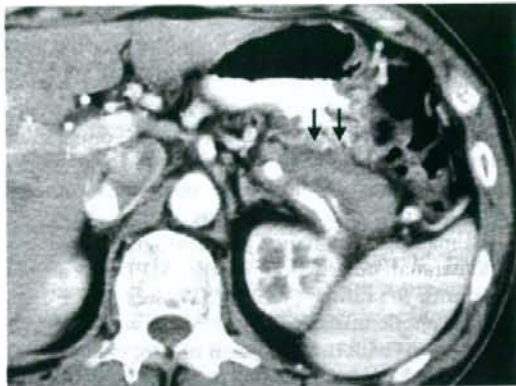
Arterial phase, contrast-enhanced computed tomography (CT) in case 4 shows a mass-like lesion in the body to tail of the pancreas, with a low-attenuated capsule-like rim (arrows).
